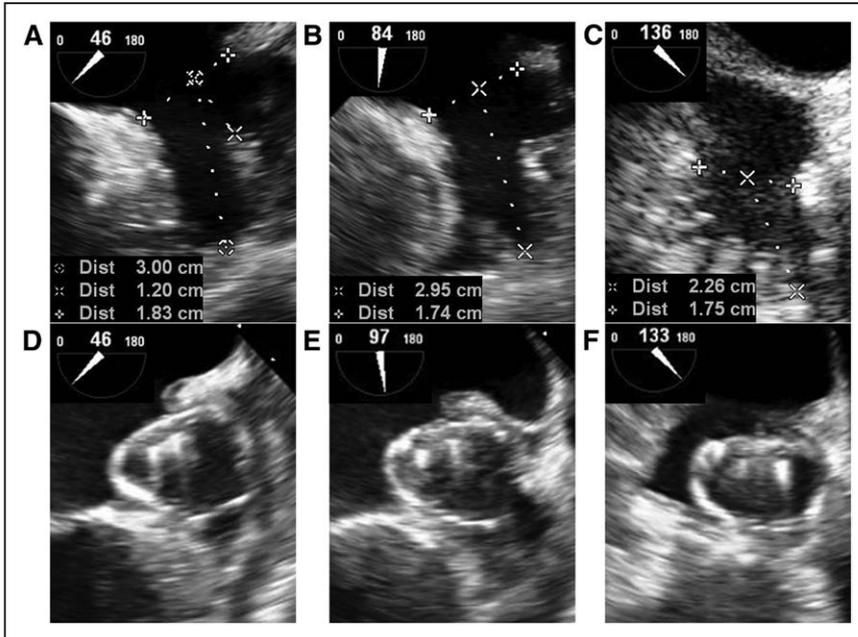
Ostial and depth measurements of the left atrial appendage on preprocedural transesophageal echocardiogram (TEE; A–C). Corresponding post-Watchman implant TEE images with the device occupying the posterior pocket (D–F).
